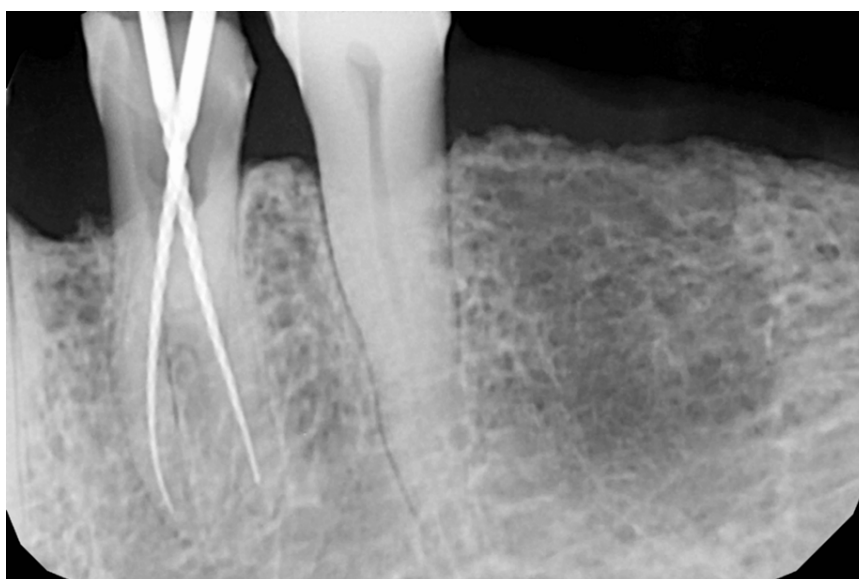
Intra-operative working-length radiograph showing mandibular left first premolar (tooth #34) with a unique radicular anatomy with 2 roots having 2 distinct canals and separate exits.
